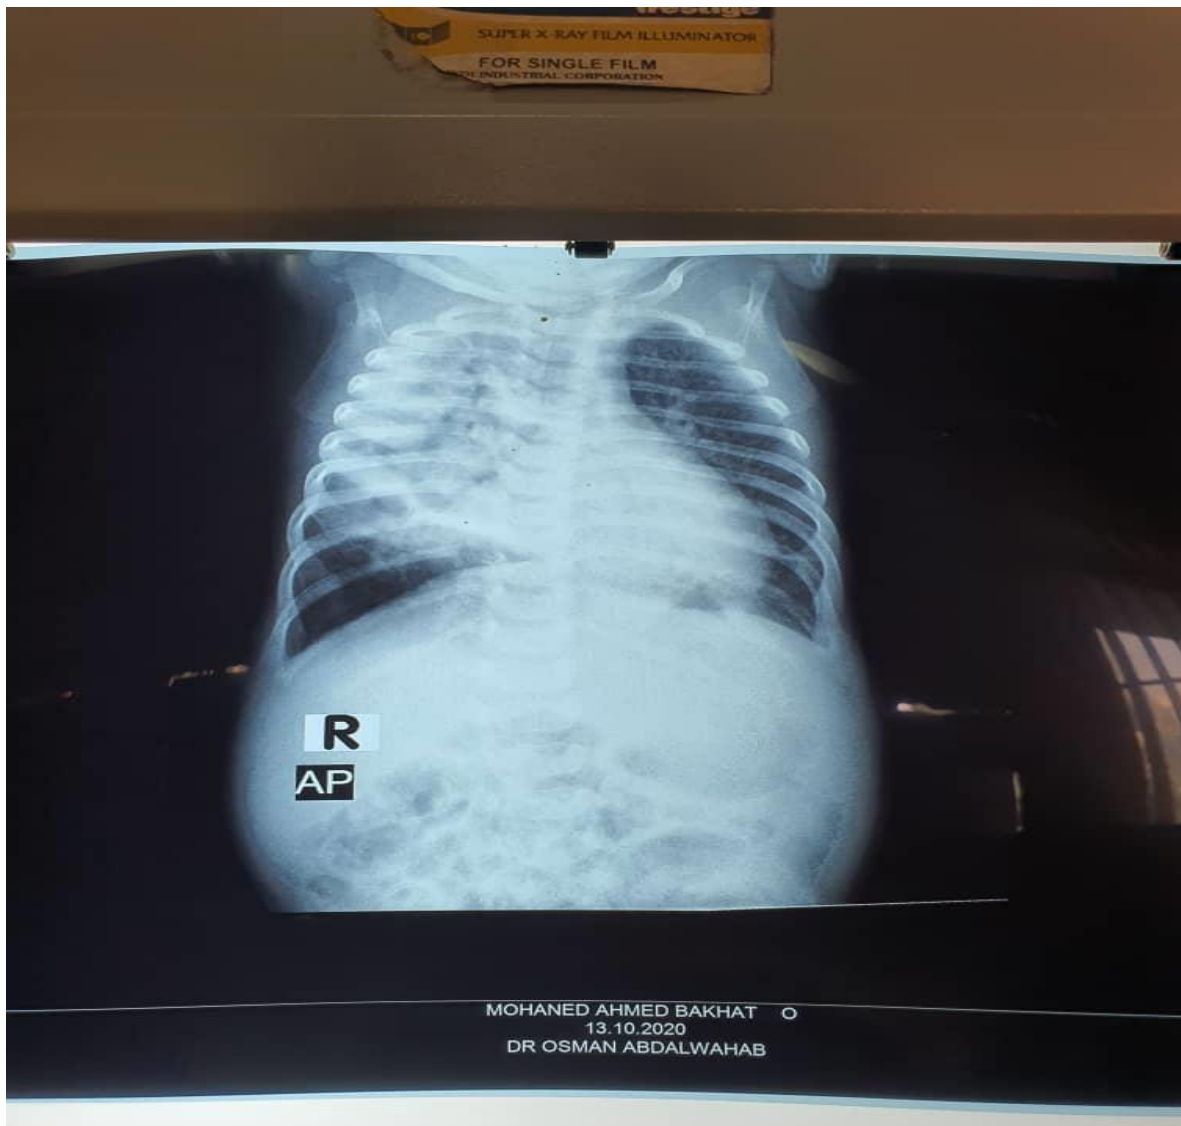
Chest X-ray in PBS patient with mild pulmonary hypoplasia and bilateral pneumonia
